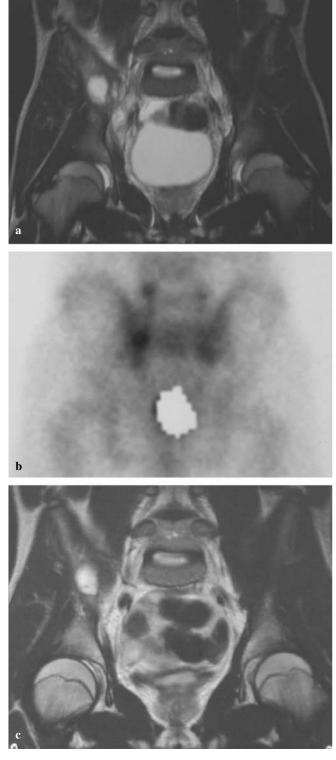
A 16-year-old boy (case 3). a MR image of the pelvis at onset. b Tc-99m-MDP bone scan at onset. c MR image after 3 weeks of antibiotic therapy
